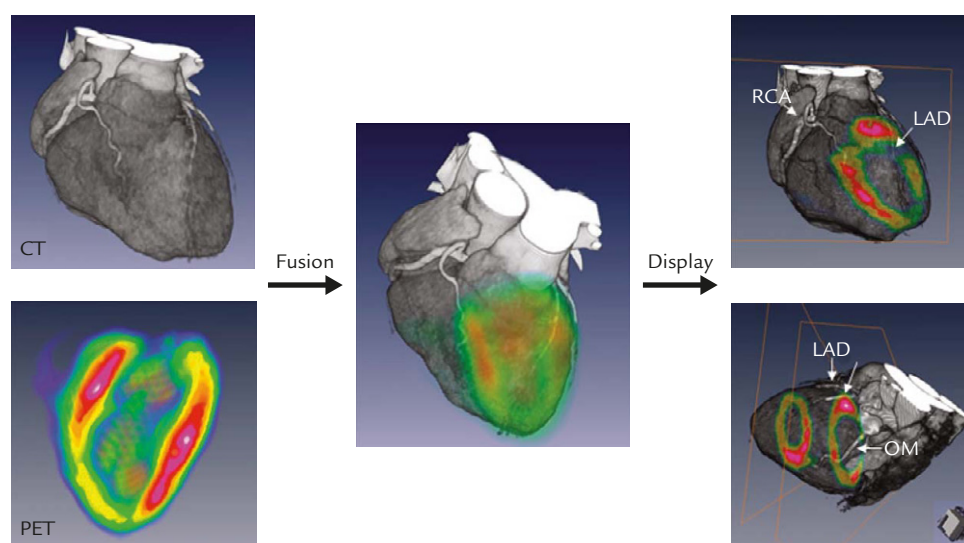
Positron emission tomography (PET)/computed tomography (CT) image fusion. CT images selected at 75% of the cardiac cycle and gated PET images of the sixth cardiac phase, equivalent to 62.5–75% R-R interval, were used for 3D reconstruction and registration with a 3D navigation scheme. CT coronary angiograms were rendered using 3D-texture volume rendering. Interactive visualization was achieved. RCA=right coronary artery; LAD=left anterior descending artery; OM=obtuse marginal artery.
